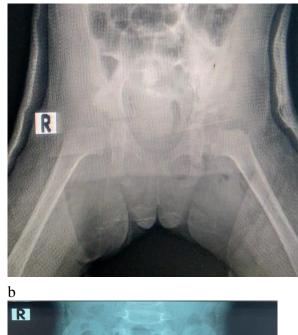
an 18-month-old female child with right DDH treated by HTIBO, a and b) preoperative x-ray. c) early post-operative follow-up x-ray of hip spica shows the HTIBO osteotomy. d) 3 months post-operative follow-up x-ray showing the healed site of HTIBO. e) a 24-month follow-up anteroposterior and lateral x-rays of the pelvis and both hip joints show reduced hip joints and improved AI with intact Shenton lines bilaterally.
